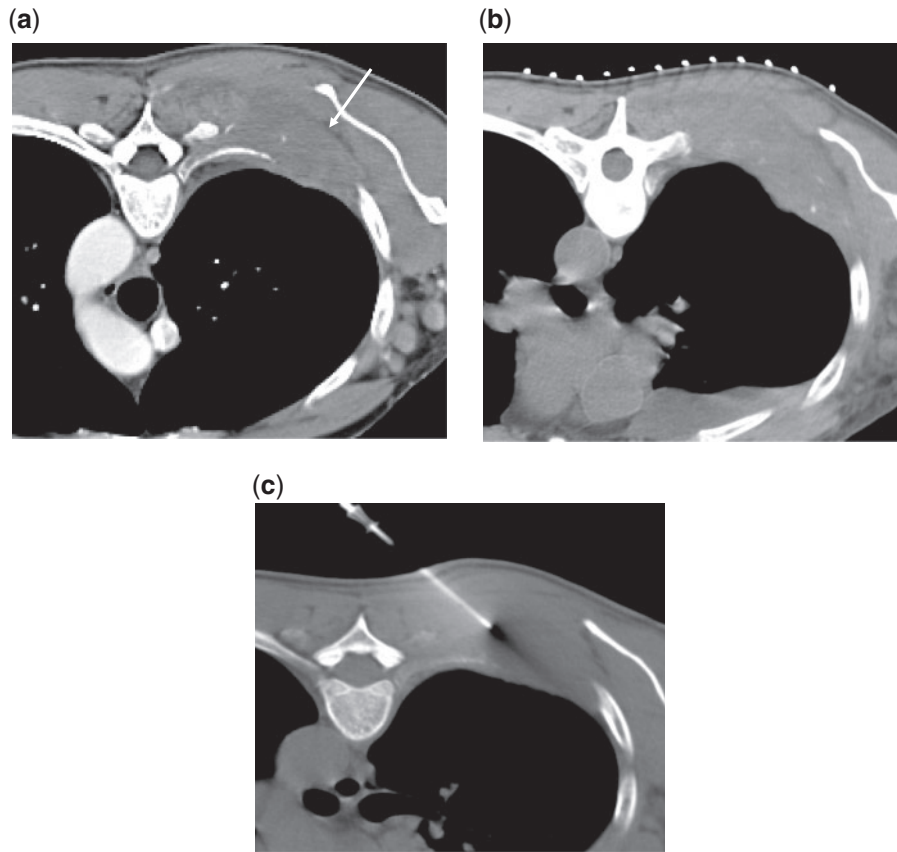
A 54-year-old woman with a history of non-Hodgkin lymphoma who presented with a chest wall mass during routine screening. (a,b) Contrast-enhanced CT scan reveals infiltrative enhancing soft-tissue mass in the right posterior chest wall (arrow). (c) Under CT guidance, 18-gauge \times 9 cm biopsy needle (arrow) was inserted into mass; cytopathology revealed non-Hodgkin lymphoma, large B cell type.
